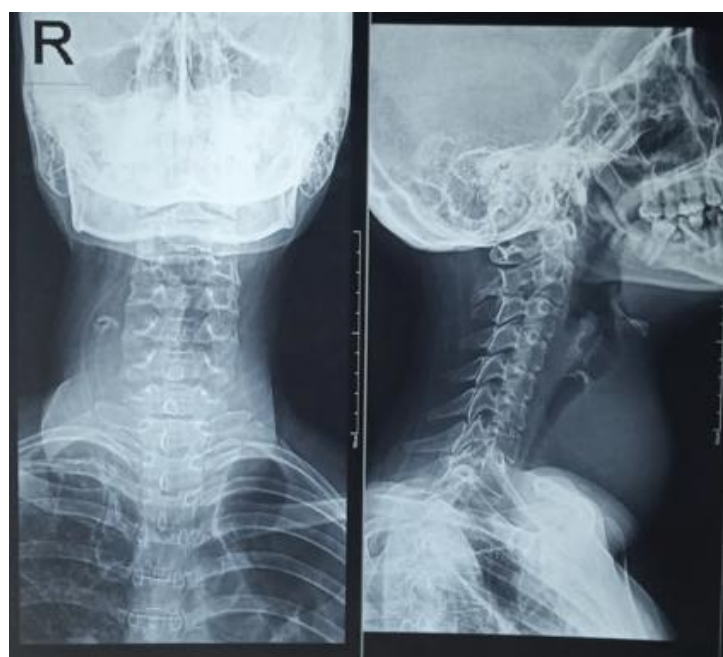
Cervical X-ray imaging.
